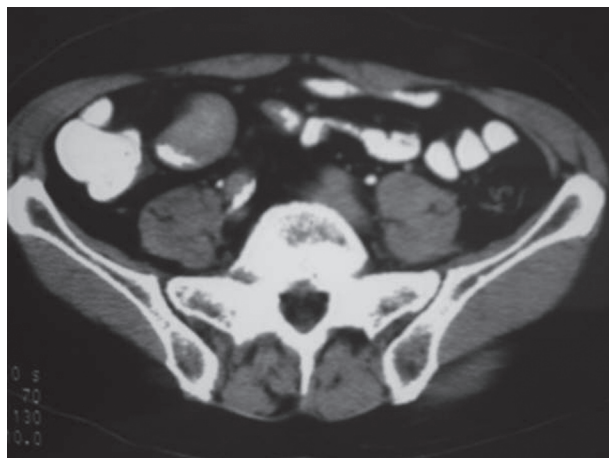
CT scan demonstrates a narrowed lumen of the distal ileum. At surgery, an adenocarcinoma of the ileum was found.
